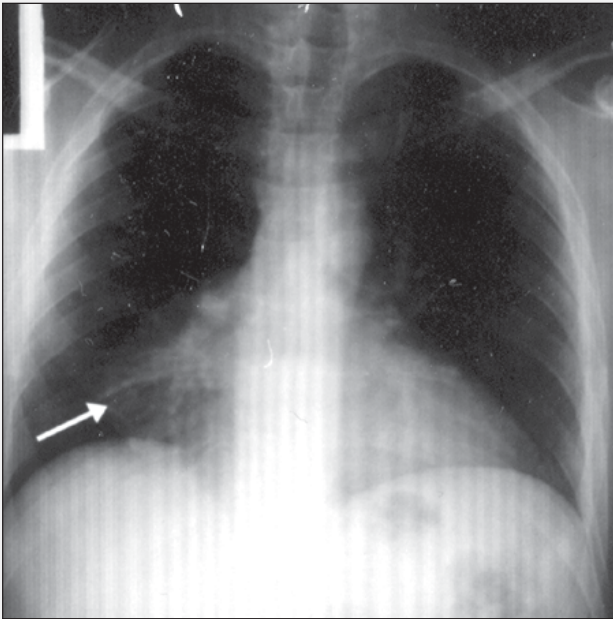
Chest radiography (PA) suggesting an expanding lesion in the anteroanterior mediastinum in continuity with the cardiac image.
